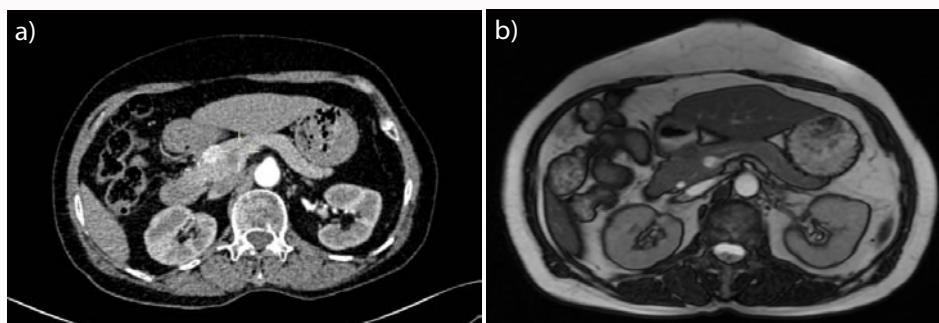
Preoperative abdominal contrast-enhanced CT and MRI showing tumor at pancreas head (a: CT, b: MRI).
